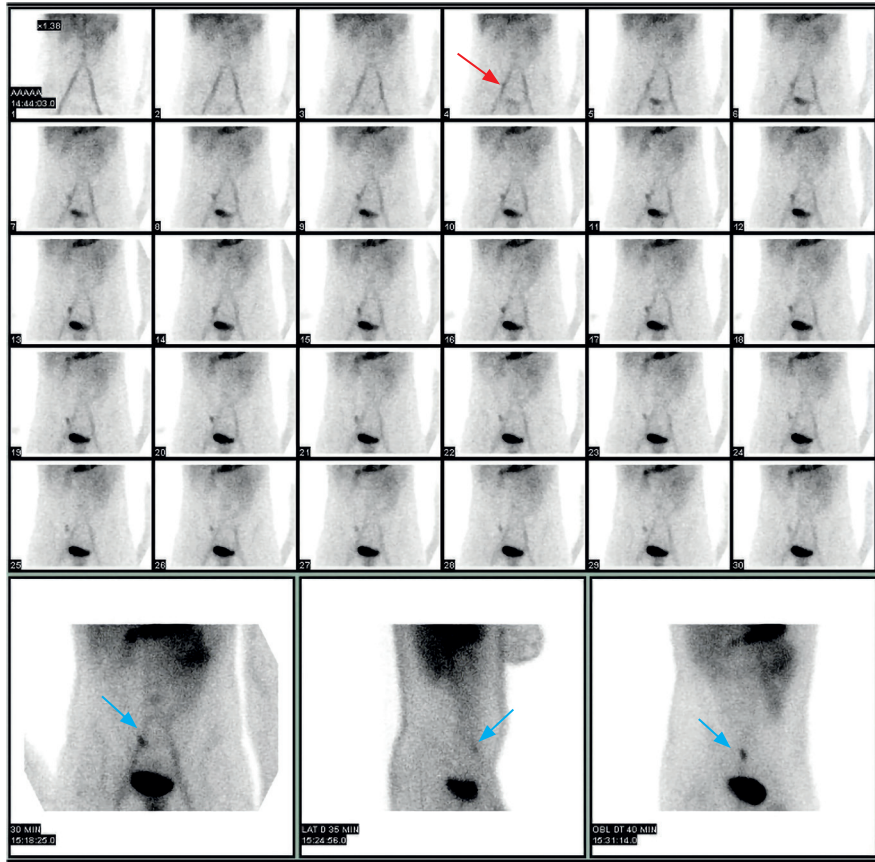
16-year-old boy with medical history of recurrent low digestive bleeding and abdominal pain. Meckel's diverticulum scintigraphy was performed: abnormal focal ^{99m}Tc NaTcO₄ uptake was observed 4–5 minutes after injection (red arrow), at same time as stomach activity. The scintigraphy findings were related to the presence of ectopic gastric mucosa in the Meckel's diverticulum. a. Dynamic anterior 1 min/frame images. b. Delayed anterior, right lateral and right anterior oblique planar 5 minutes images. Premedication with oral cimetidine.
